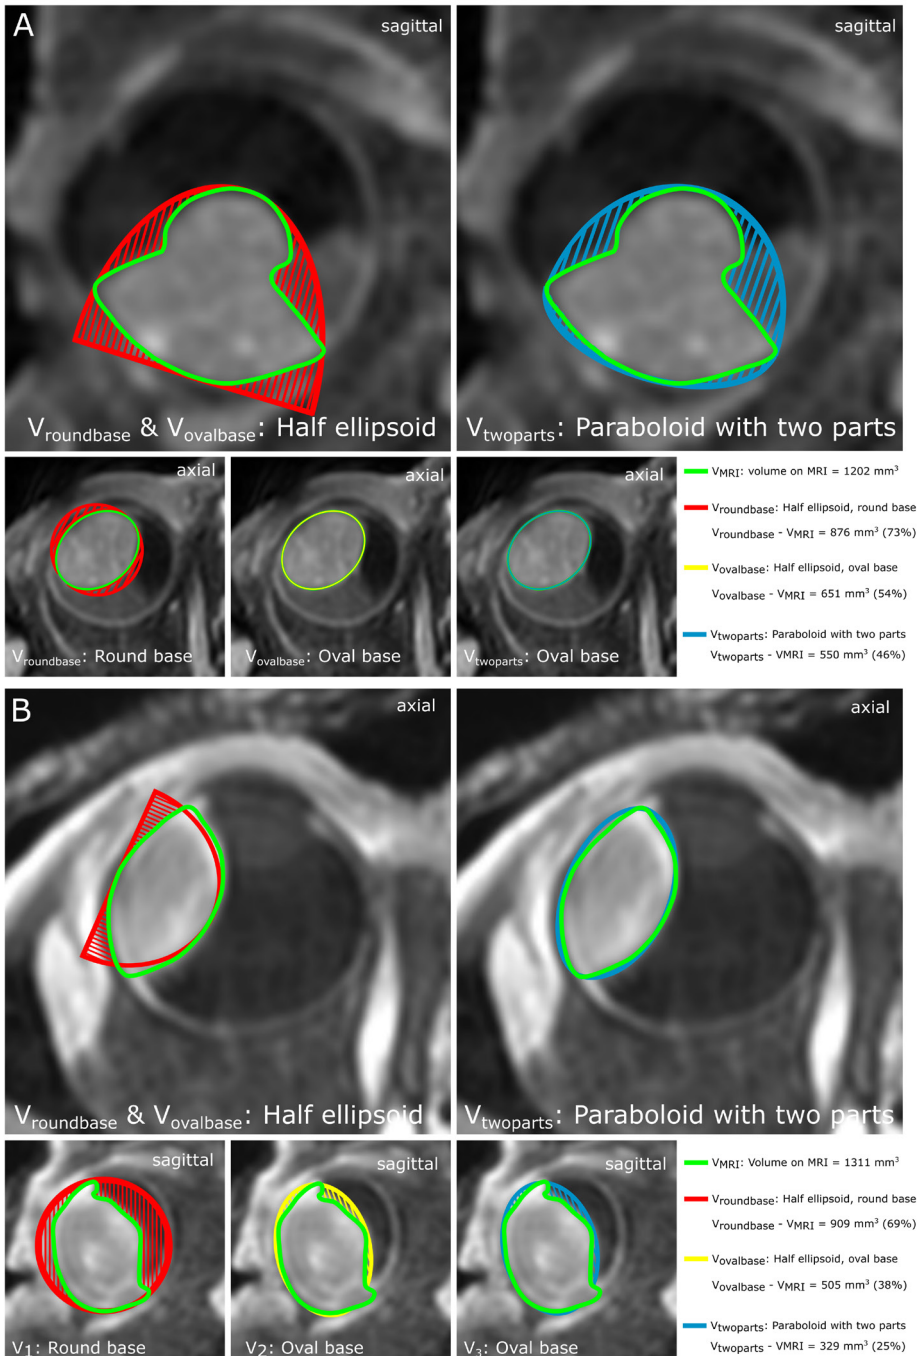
Two examples of the three tumour models and the MRI contours for patients with an irregular (mushroom) shape (A) and with a regular (dome) shape (B). Green: MRI tumour
